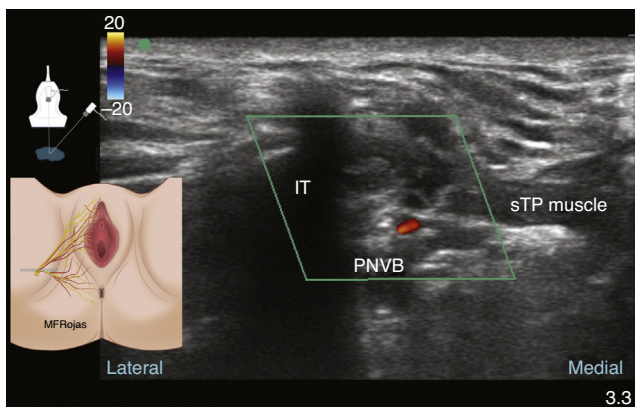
Perineal ultrasound in colour Doppler mode showing the ischial tuberosity (IT), superficial transverse perineal muscle (sTP) and the pudendal neurovascular bundle (PNBV).
